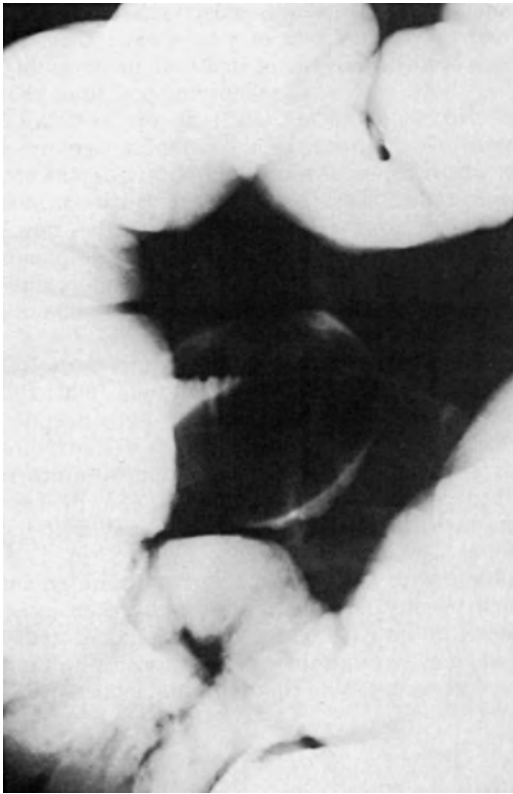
Intussusception. A persistent filling defect is seen on barium enema examination in the ileum in this child who had a normal-appearing colon. Because the sonogram that preceded this study showed the intussusception, it was necessary to reflux into more ileal loops than usual to confirm and treat the problem.
